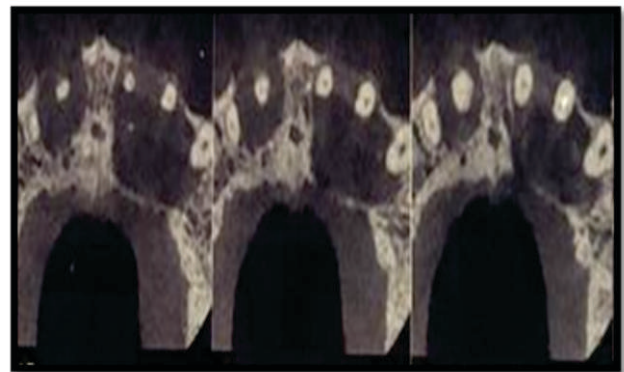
CBCT representation of a large osteolytic bone defect.
